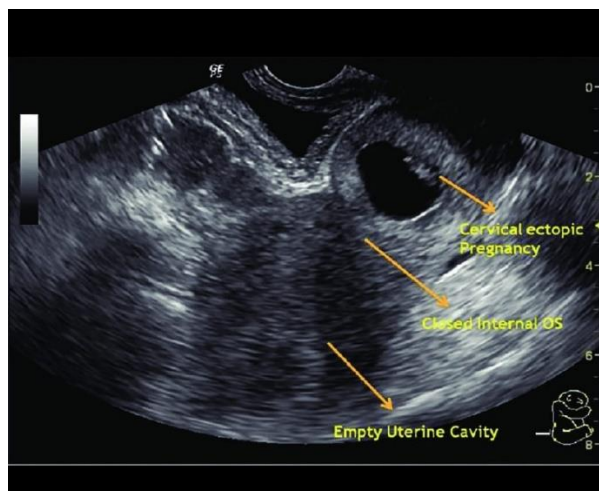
Ultrasound figure of cervical pregnancy.
